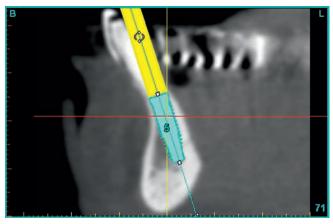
I, Image created with the Simplant CT planning software (Materialise, Brussels, Belgium). The CT scan was loaded and converted to allow for virtual implant placement. The implant can be placed within the bone and easily angled to emerge just lingual to the planned incisive edge of the mask.
